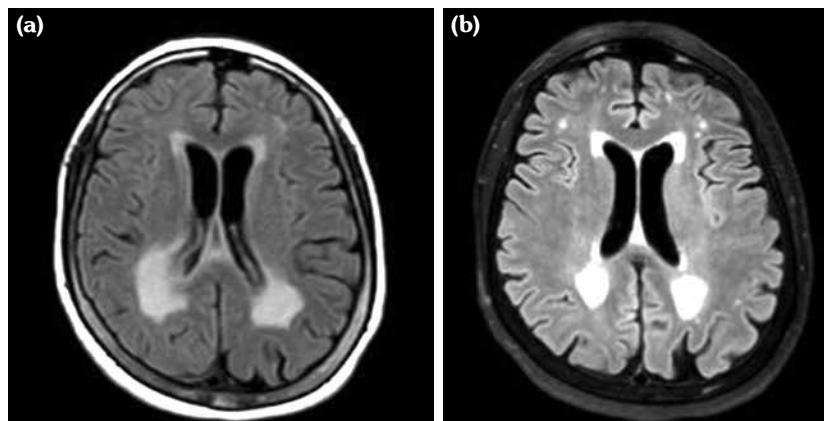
Brain magnetic resonance imaging, (a) before and (b) after treatment with intravenous steroids and rituximab. Further decrease in the FLAIR signal surrounding the lateral ventricles and in the areas of enhancement.
